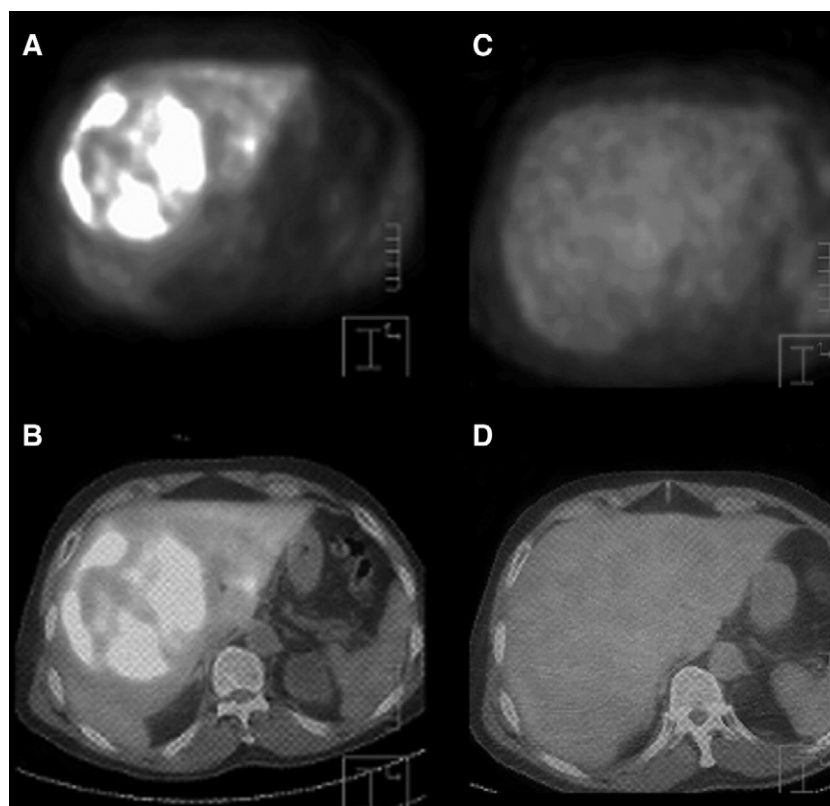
Large liver mass in a patient with hepatitis C virus infection. A liver lesion with intense FCH uptake (maximum standardized uptake value = 20) was noted on PET (A). The lesion measures 12.5 cm and involves Couinaud segments VI and VIII on FCH PET/CT (B). No abnormal uptake is noted on FDG PET (C) and PET/CT (D). Grade 2 well-differentiated hepatocellular carcinoma was confirmed after surgery.
